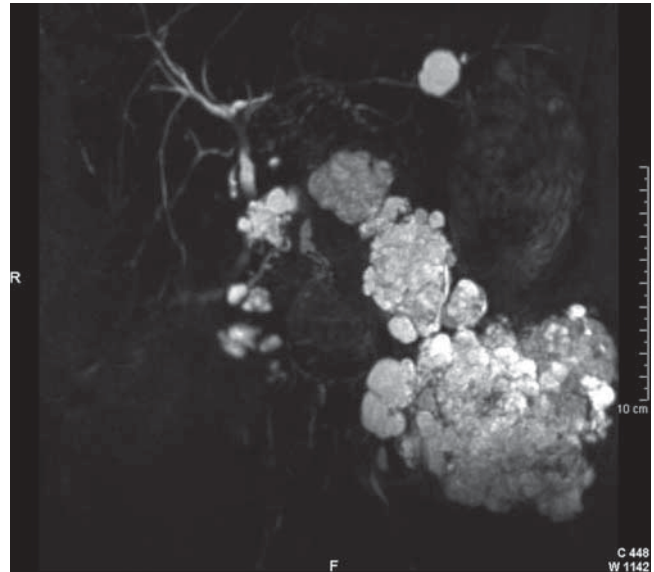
MR image (T2-weighted) showing the cystic lesions affecting the whole pancreas at the time of diagnosis
